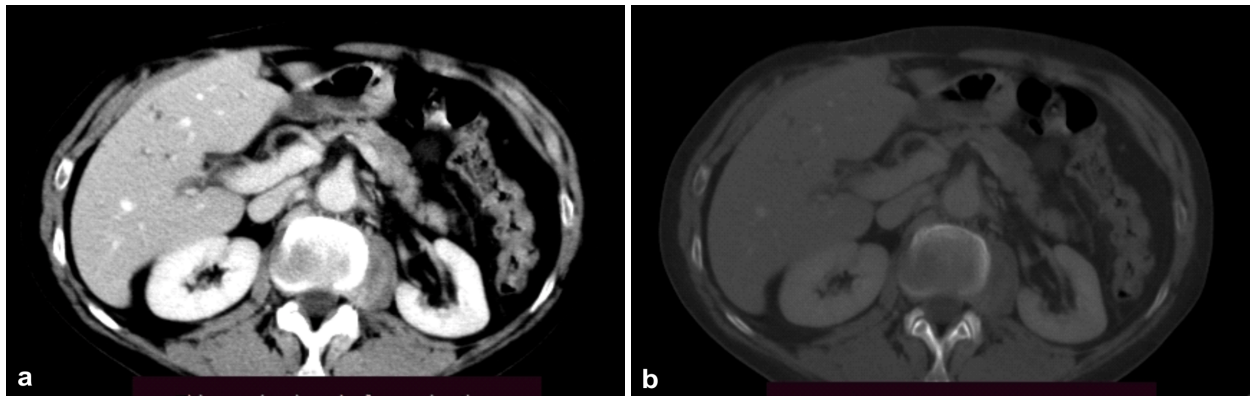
(a and b) CT axial sections (parenchymatous and bone window): contrast enhancement of the psoas muscle, without bone invasion.
